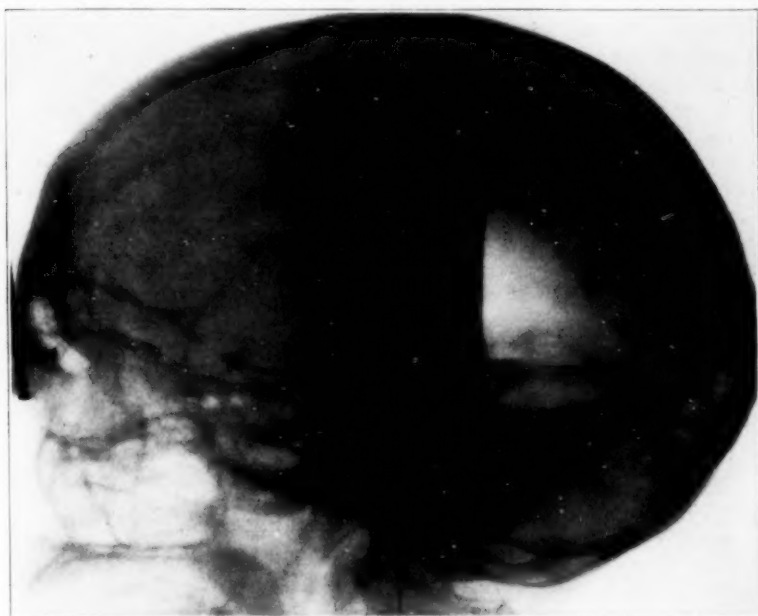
Roentgenogram taken with the brow down. Note air in the posterior horns of both lateral ventricles, also in the midline cavity over the roof of the midbrain. The posterior clinoids have been absorbed.
